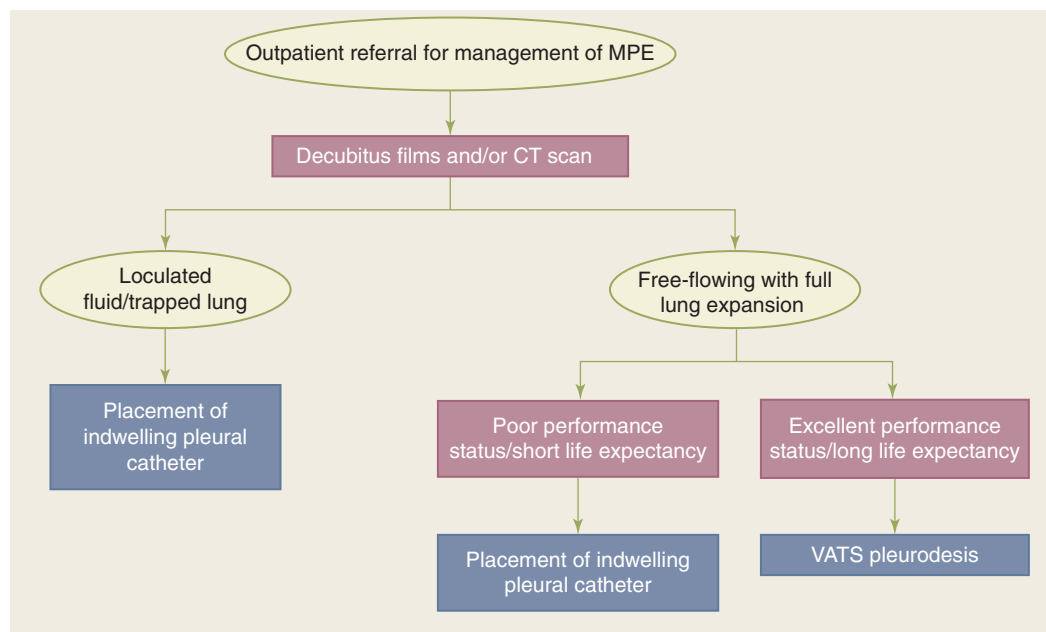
Treatment decision algorithm for the management of malignant pleural effusion (MPE). CT = computed tomography; VATS = video-assisted thoracic surgery.
